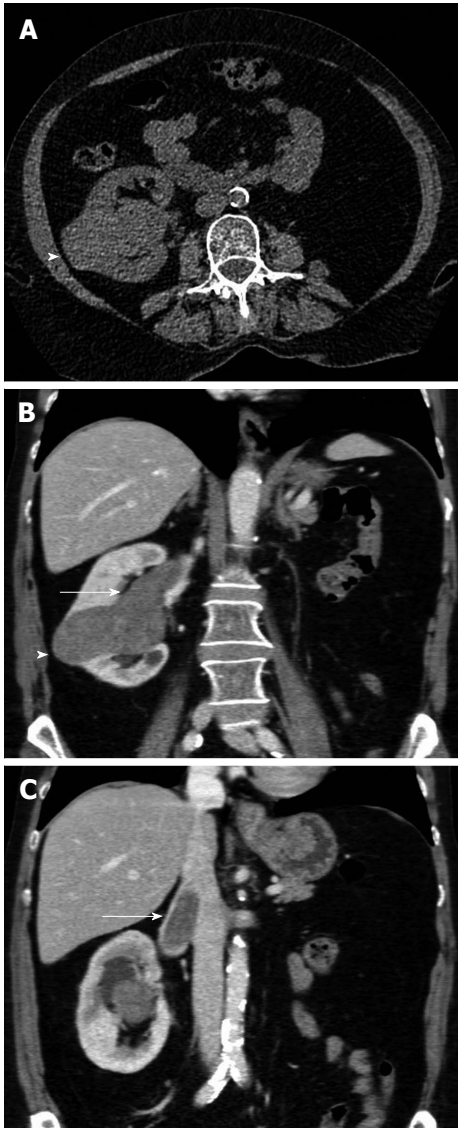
The 65-year-old woman with papillary renal cell carcinoma of the right kidney and tumoral invasion of the ipsilateral renal vein and the inferior vena cava (stage T3b, grade 2). The patient had left radical nephrectomy years ago for renal cell carcinoma. A: Transverse unenhanced computed tomography (CT) image shows a lobular right renal mass (arrowhead), located in the interlobar region. The mass is relatively homogeneous, slightly hyperdense (CT density: 40 HU), when compared to the normal renal parenchyma; B and C: Contrast-enhanced coronal multiplanar reformations during the corticomedullary phase depict right renal tumor, with moderate, homogeneous enhancement (arrowhead, mean CT density: 65 HU). Venous tumour thrombus is diagnosed as a filling defect within right renal vein and the infrahepatic part of the inferior vena cava (arrow). Neoplastic thrombus is seen extending directly from the neoplasm, enhancing with a similar pattern with primary malignancy.
